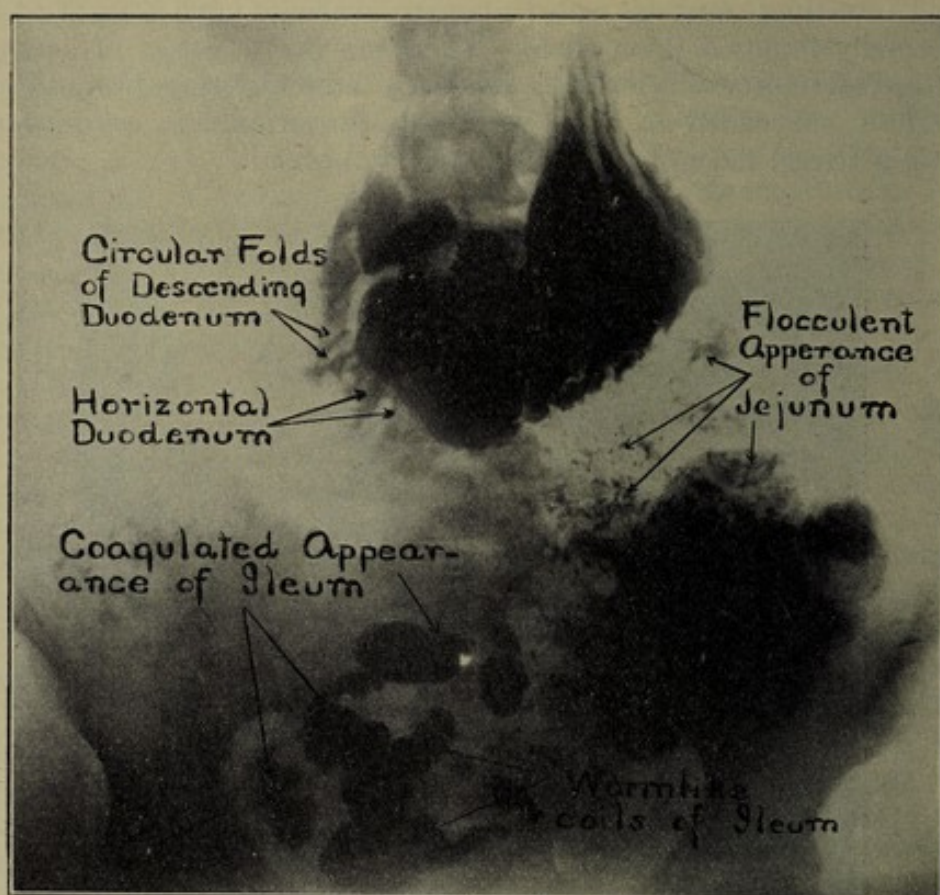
Usual roentgenographical appearance of cap, duodenum, jejunum, and ileum.
